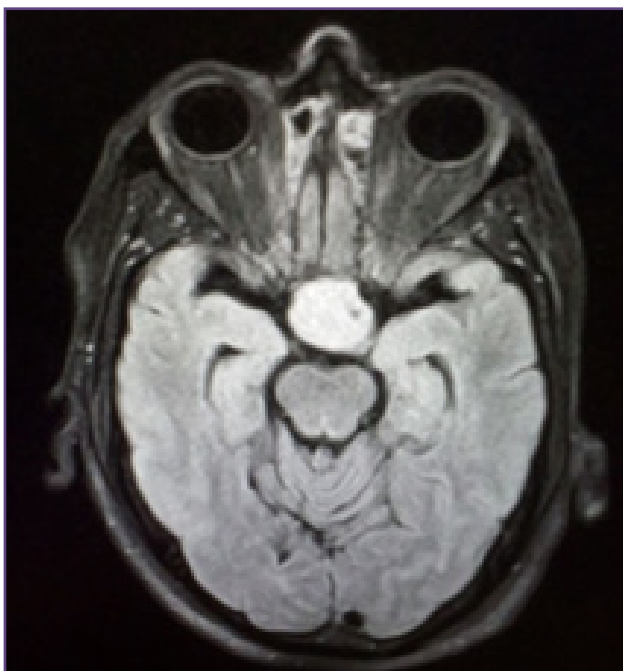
T2 weighted coronal MRI image shows a well defined, solid intensely enhancing sellar mass (pituitary adenoma).
